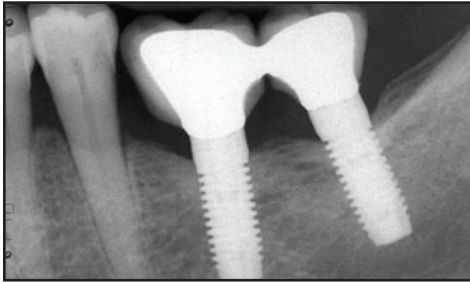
Five-year follow-up X-ray.
